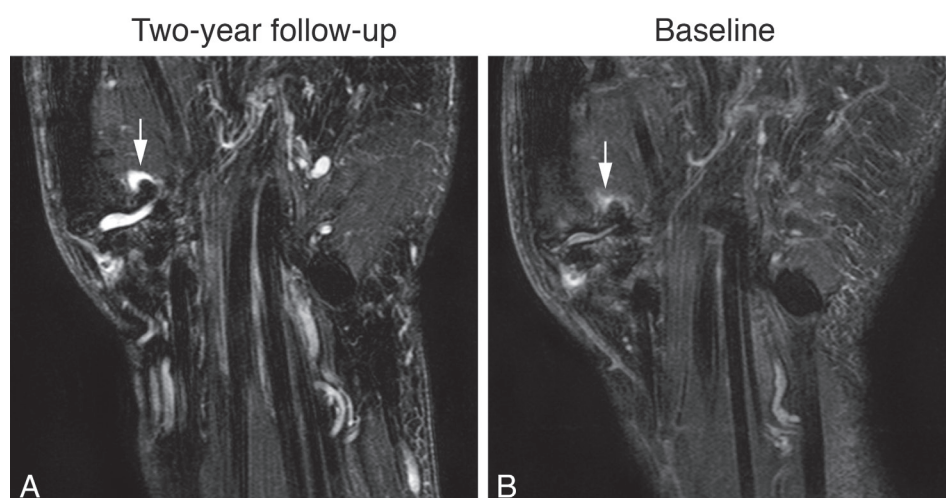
Coronal fat saturated T2-weighted FSE MR imaging showing increase in synovitis in the CMC-1 joint (arrows) at the two-year follow-up visit (A) compared to baseline (B).
